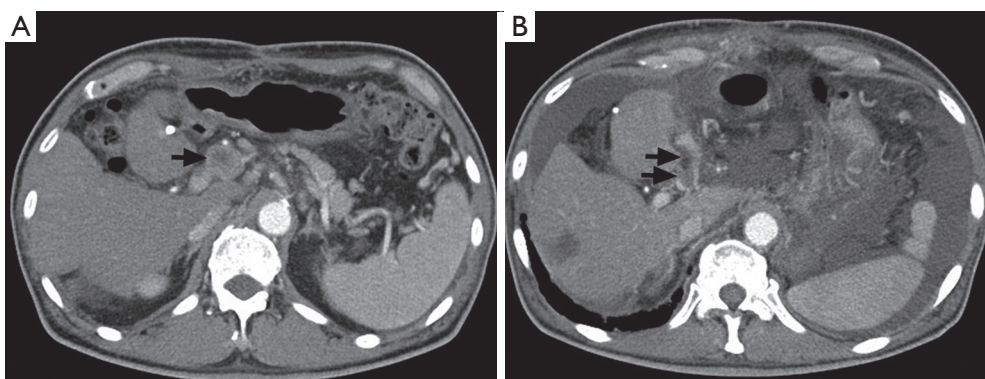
Contrast-enhanced CT imaging of patient 2 before (A) and after (B) sorafenib therapy. At the time of admission with jaundice, the thrombus in the portal vein extended into the intrahepatic branch. CT, computed tomography.
